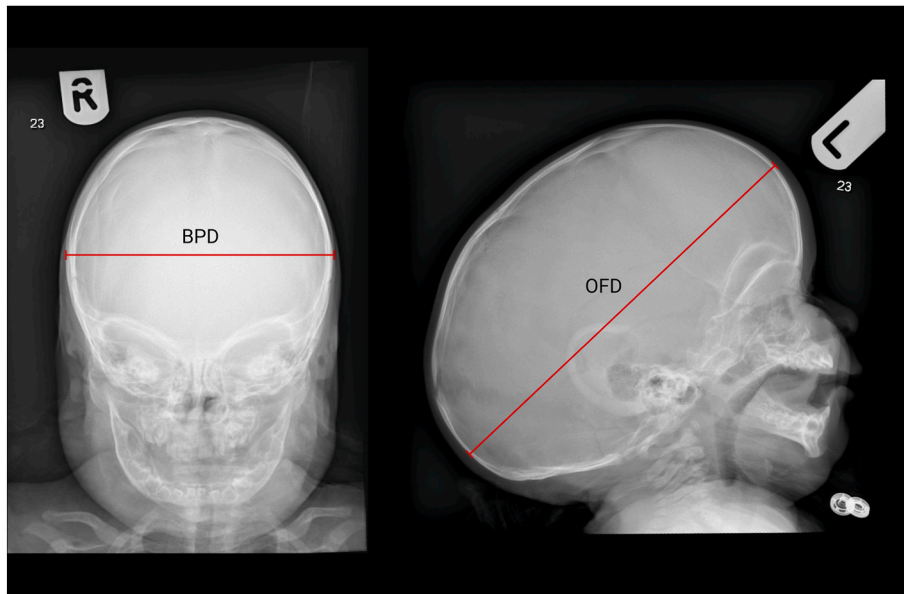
Cephalic index measurement on a pre-operative X-ray of a scaphocephalic patient. BPD and OFD were measured to include calvarial bone diameter.
